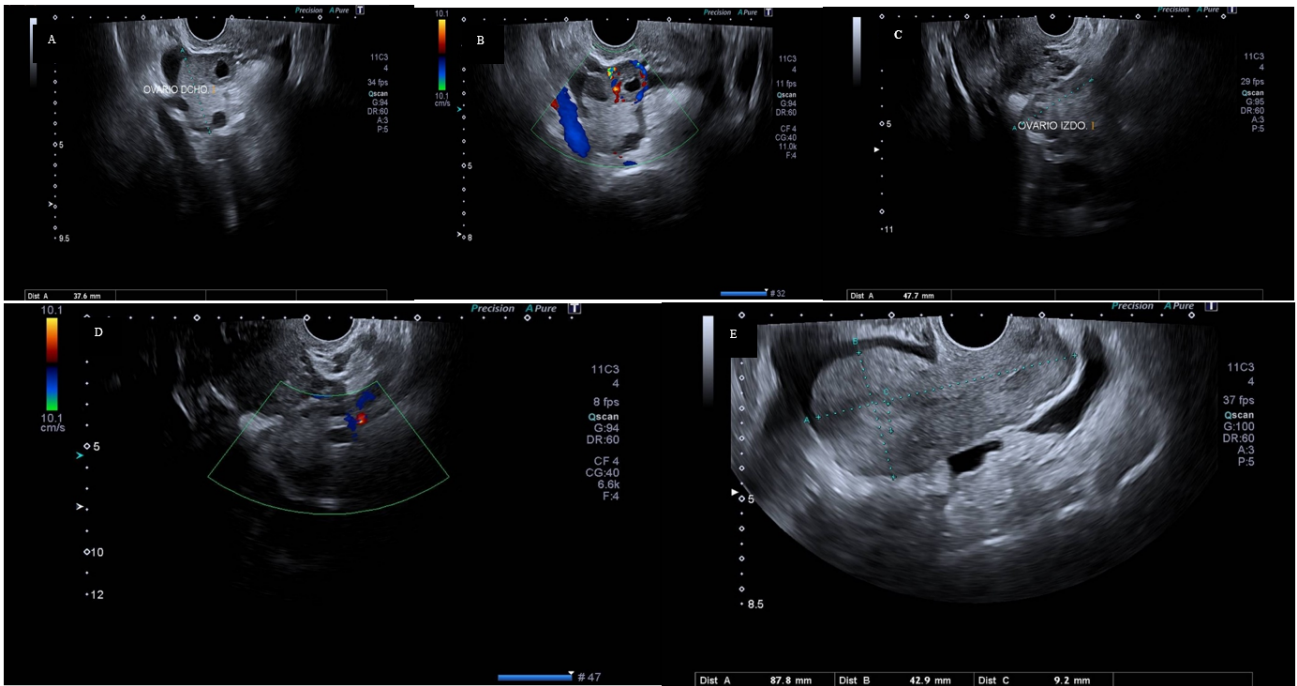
Transvaginal ultrasound. (A) Right ovary with hyperechoic stroma and anechoic cyst compatible with lutein cyst in resolution. (B,D) Both ovaries without abnormal Doppler uptake. (C) Left ovary with characteristics similar to those described in the right ovary. (E) Uterus with regular contoured and morphology with homogenous endometrium. Moderate amount of fluid in Douglas.
